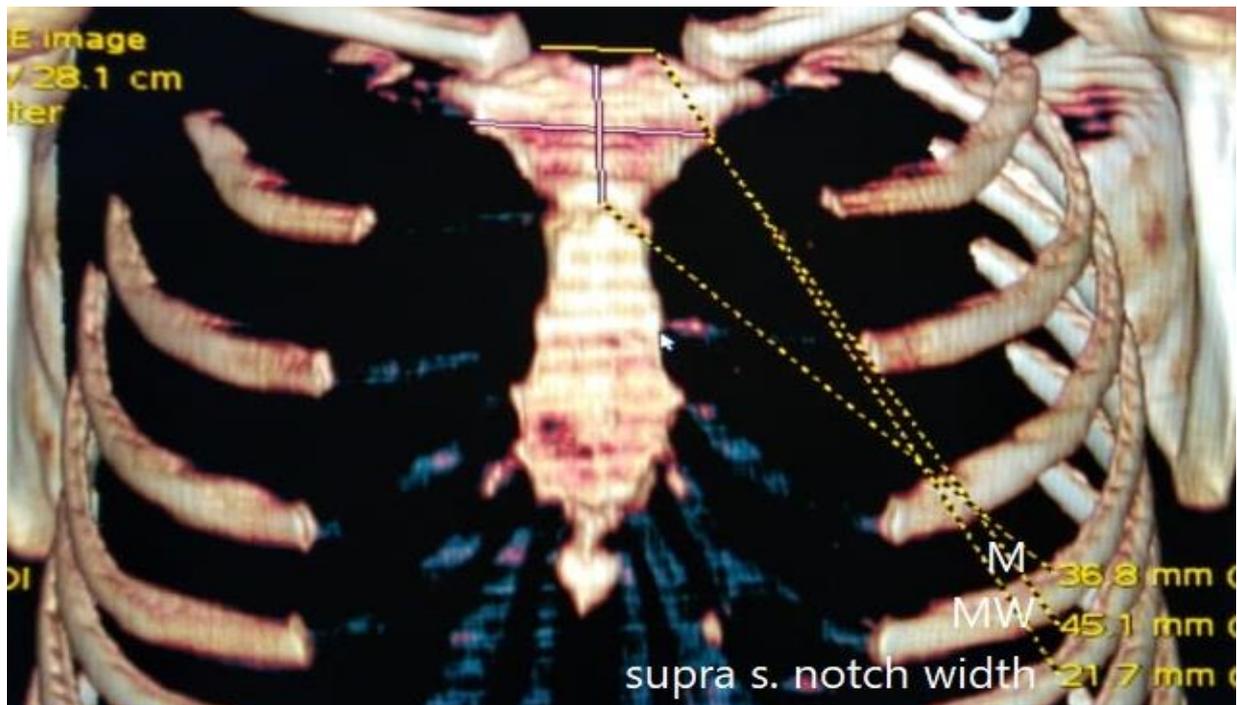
Computed tomography imaging showing manubrium width, manubrium length and width of supra sternal notch in one of the female participants; (M) manubrium length; (MW) manubrium width.
